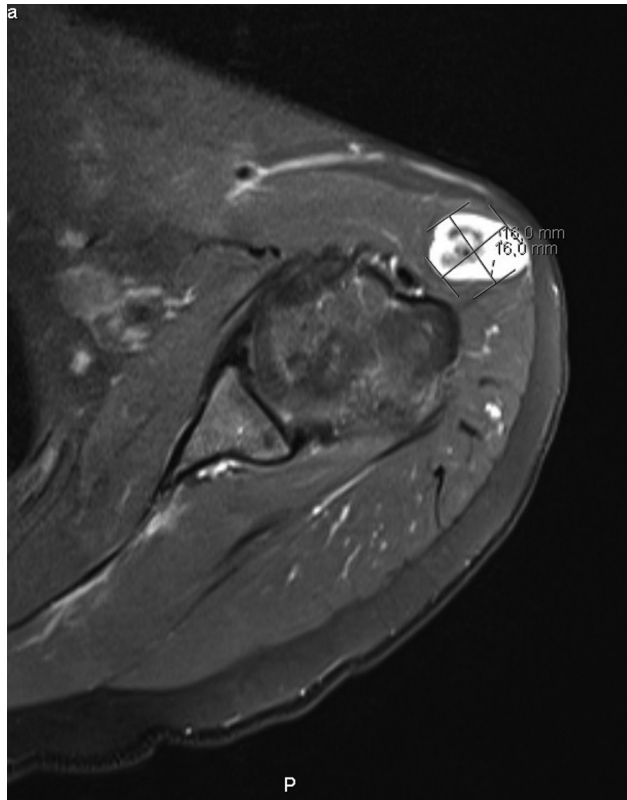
Magnetic resonance imaging of intramuscular hemangioma of the deltoid.
